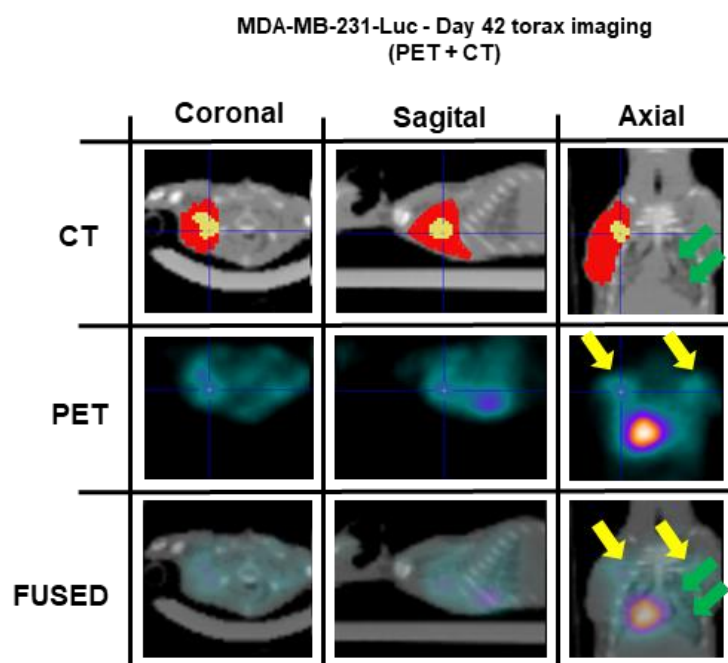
Thoracic region in detail. Characteristic intraparenchymatous lung metastasis detected by CT (green arrows). In addition, the swollen left ALN detected by CT (red region), but only an active metastatic region was detected by PET (yellow region) within the ALN mass.
